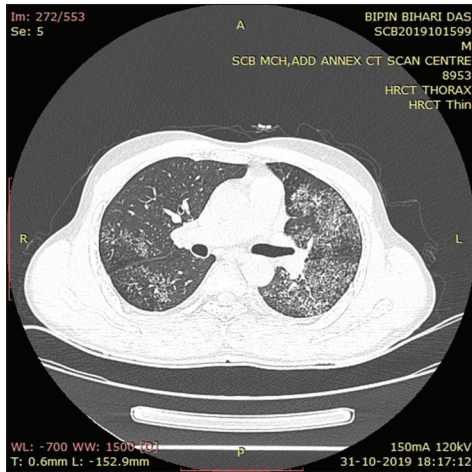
Axial section of high-resolution computed tomography of a 48-year-old diabetic male presented with cough, fever, and sputum production thorax showing bilateral lung field areas of nodules in tree in budding phase pattern
